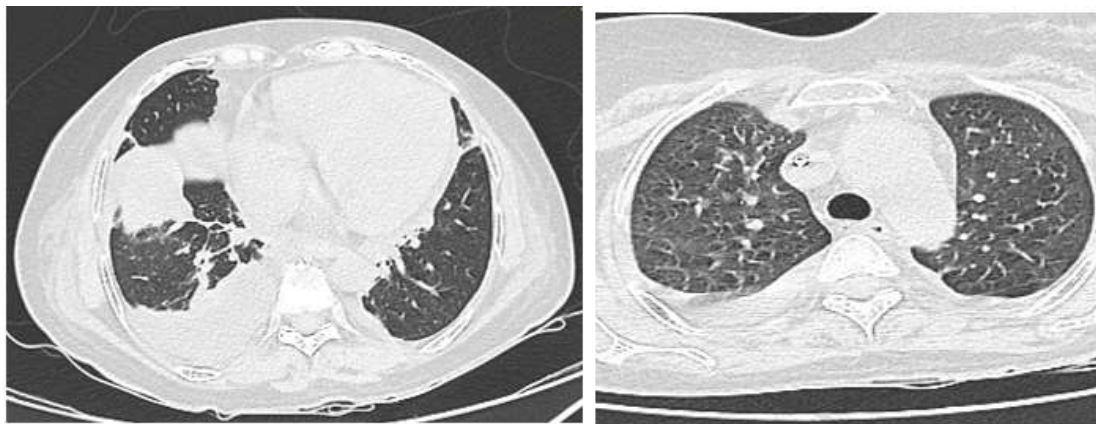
CT-Chest shows patchy areas of ground glass opacities in bilateral lung fields, predominantly in peribronchovascular areas with bilateral mild pleural effusion (right >left) with fissural extension with sub-segmental collapse of underlying segments suggestive of Diffuse alveolar hemorrhage (DAH)
